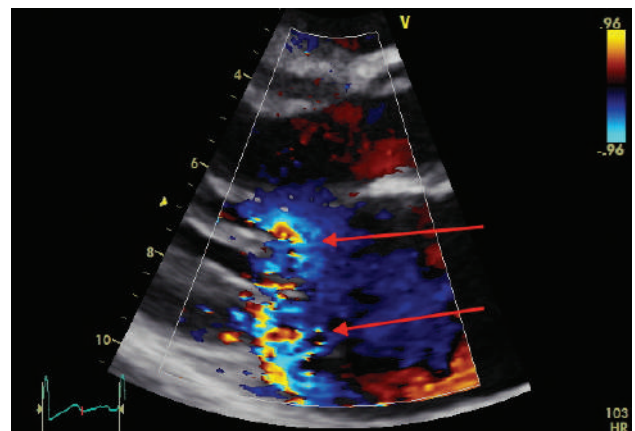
Rheumatic mitral valve; mitral regurgitation due to RHD is commonly eccentric with a posteriorly directed jet seen on colour Doppler (red arrows)
